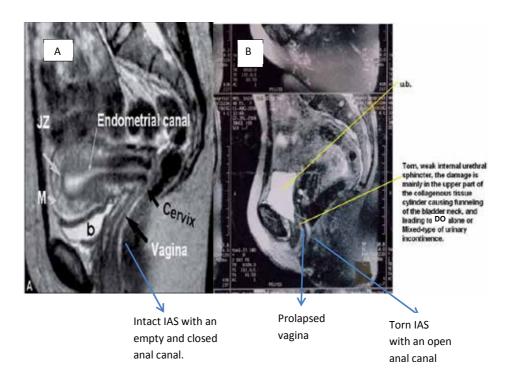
MRI images of a normal continent woman (A) with intact IUS, IAS with a closed empty anal canal and normal non-prolapsing vagina. Image (B) is of an incontinent patient with torn IUS and torn IAS and prolapsed vagina.
